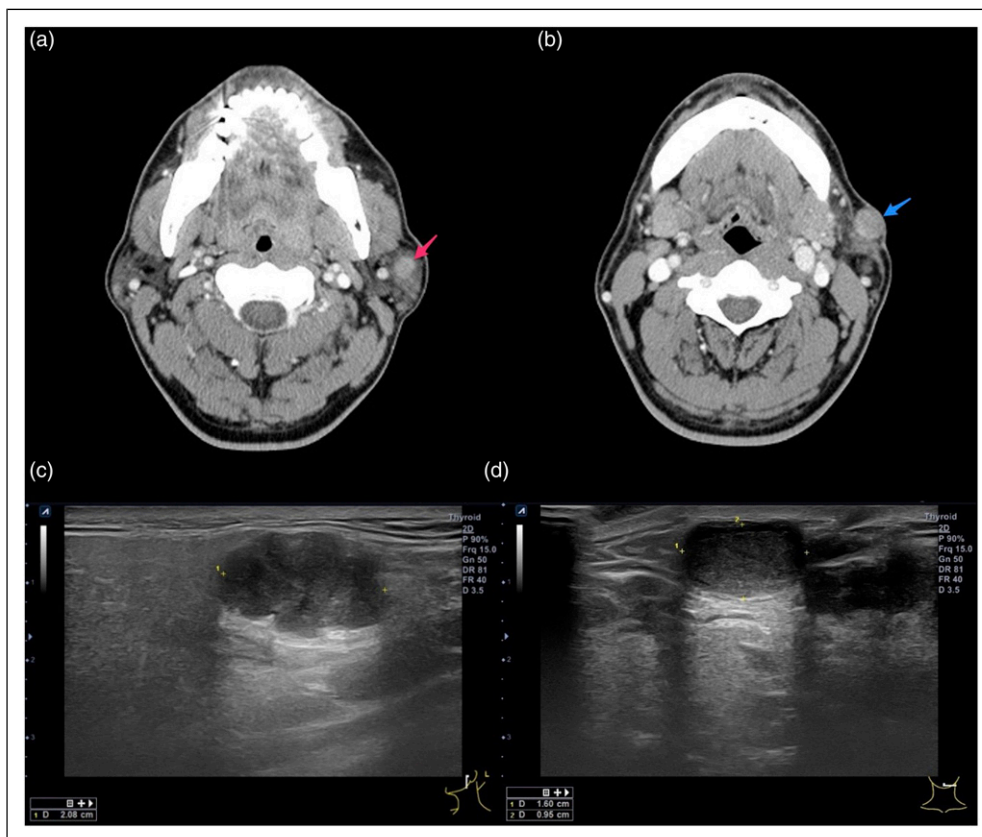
Preoperative evaluation of tumors. Enhanced neck CT (a, b) and ultrasound showed ovoid masses with slight enhancement in left parotid gland and lateral neck level II (c, d).
